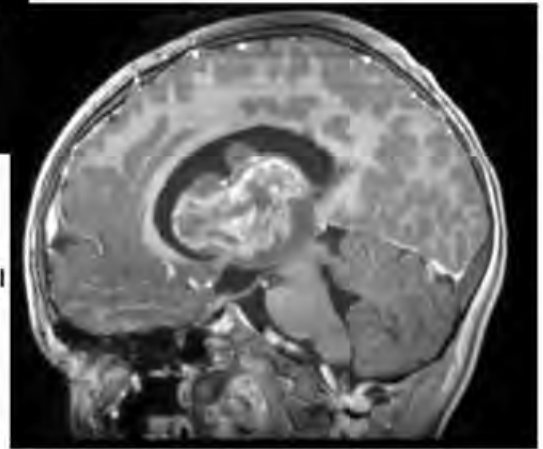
Sagittal T1-weighted C+ image showing heterogeneously enhancing mass arising from left thalamus.
